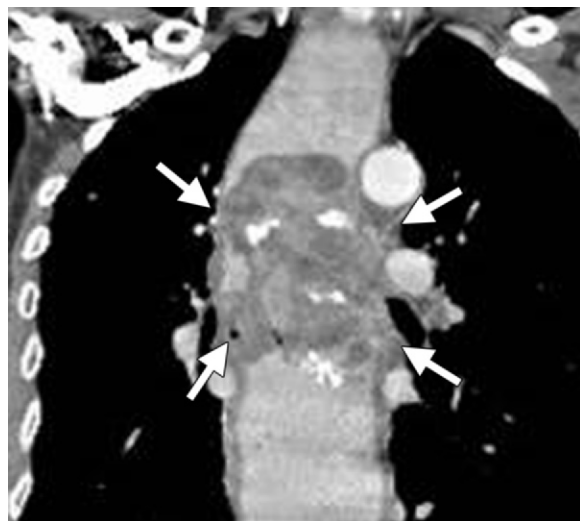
Esophageal sarcoma. Coronal contrast-enhanced multiplanar reformatted chest CT image shows dilatation of the esophagus by a large, bulky soft-tissue mass (arrows) that contains calcifications and expands the lumen. Pathologic analysis revealed esophageal sarcoma.
